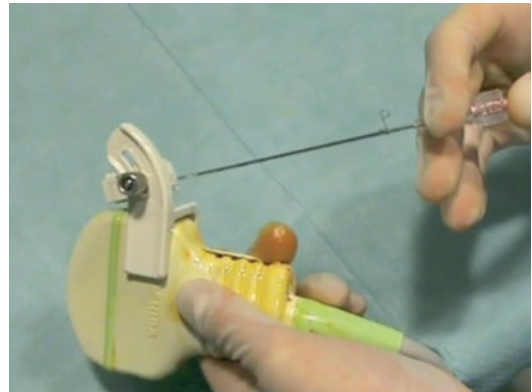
Ultrasound guide for percutaneous biopsy
